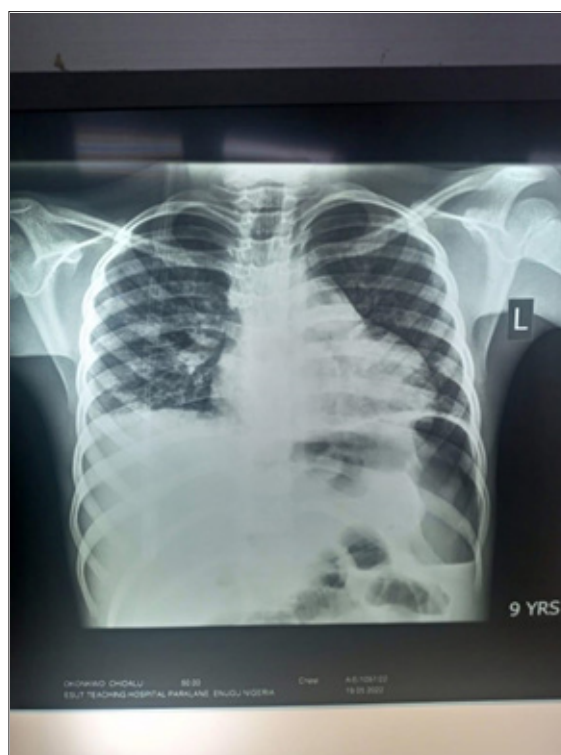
Plain thoracoabdominal radiograph showing free air under the left hemidiaphragm
